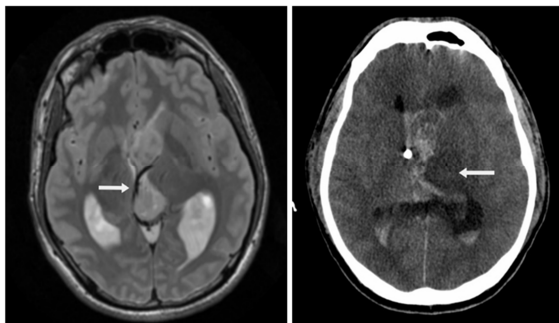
Postoperative IVH and left thalamus edema in a 25-year-old man. (left) Before operation. Axial T2-weighted image shows a typical CN abutting the internal cerebral veins (arrow). (right) After operation. Nonenhanced axial CT image shows left thalamus edema (arrow). Venous drainage insufficiency/damage may explain this imaging finding. IVH is also present.
